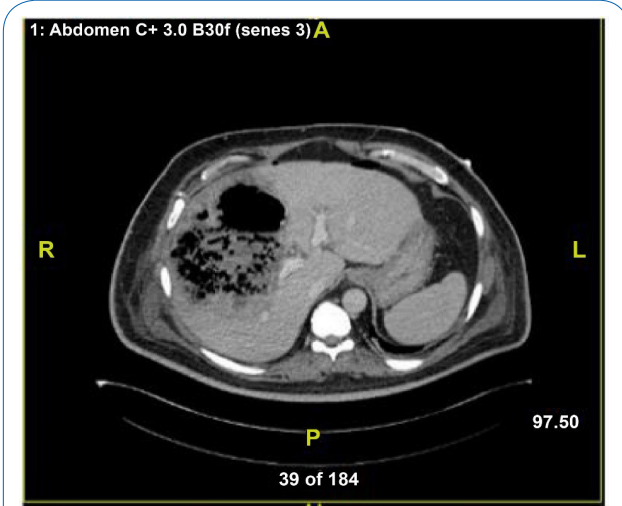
Abdominal computed tomography performed four days after admission, showed an enlarged liver and a large fluid density lesion.
